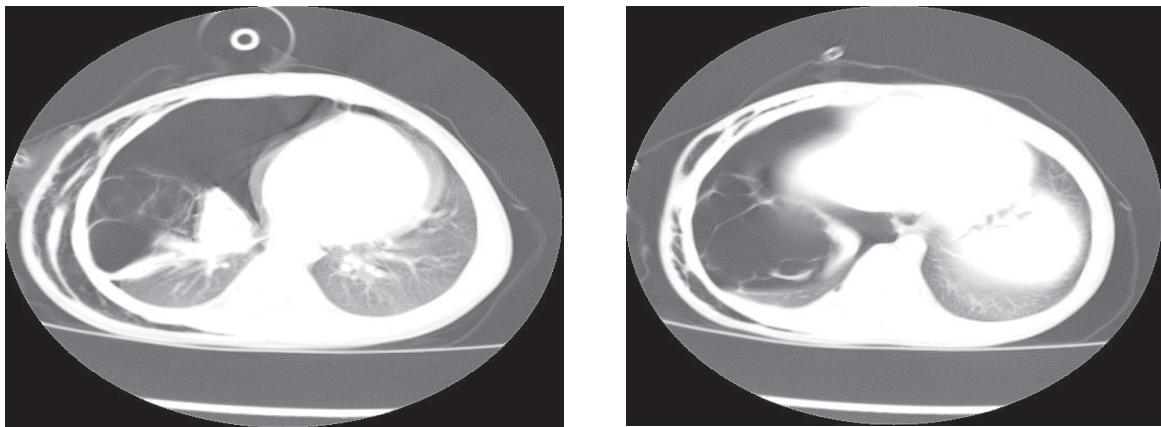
(A-B). Chest CT on admission (June 2017)
